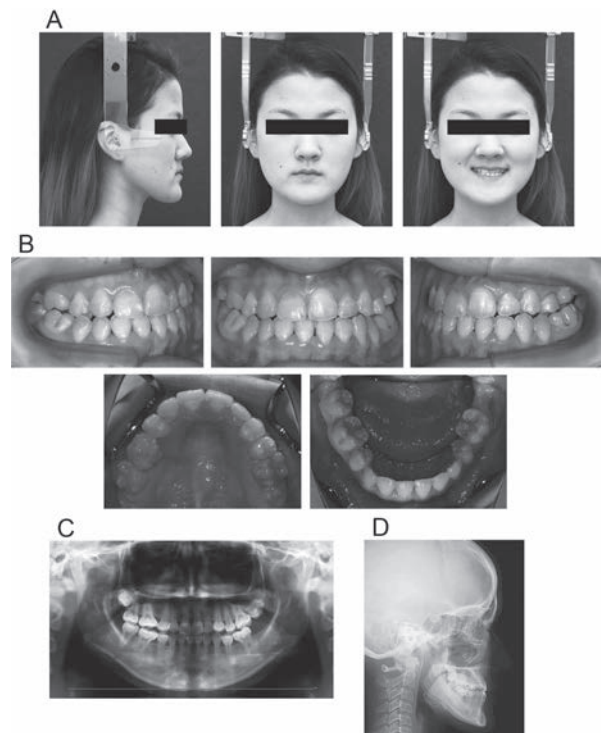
Post-active treatment records (age: 19 years and 11 months). A, Facial photographs. B, Intraoral photographs. C, Panoramic radiographs. D, Lateral cephalograms.
